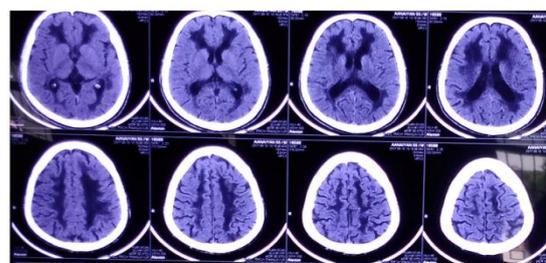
Axial CT images showing deep sulci, dilated ventricles and periventricular hypo-densities (Ischemic changes) s/o generalized cerebral atrophy. All these changes are s/o small vessel disease.
